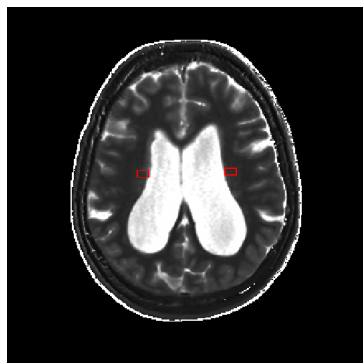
The three different types of maps obtained from a synthetic MRI scan are a)  $T_1$ , b)  $T_2$  and c) PD.
